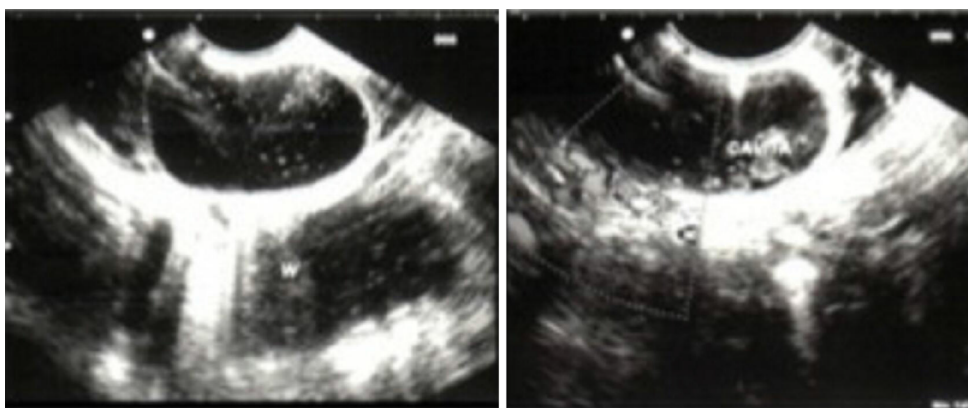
Endoscopic ultrasound. The probe is inside the duodenum, and the common wall separates the duodenum and the duodenal duplication.
